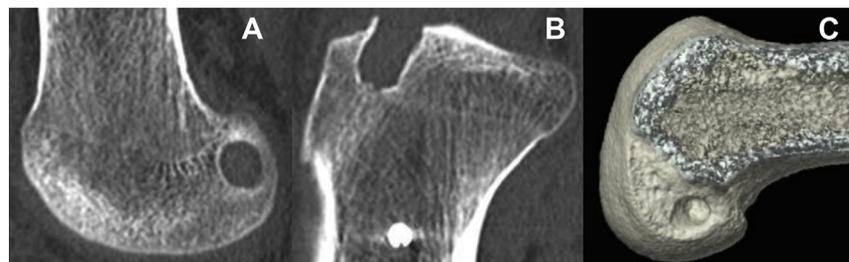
Computed tomography image of anterior cruciate ligament reconstruction. (A) Sagittal view with a femoral tunnel position. (B) Sagittal view with a tibial tunnel position. (C) 3D reconstruction with a femoral tunnel position.
